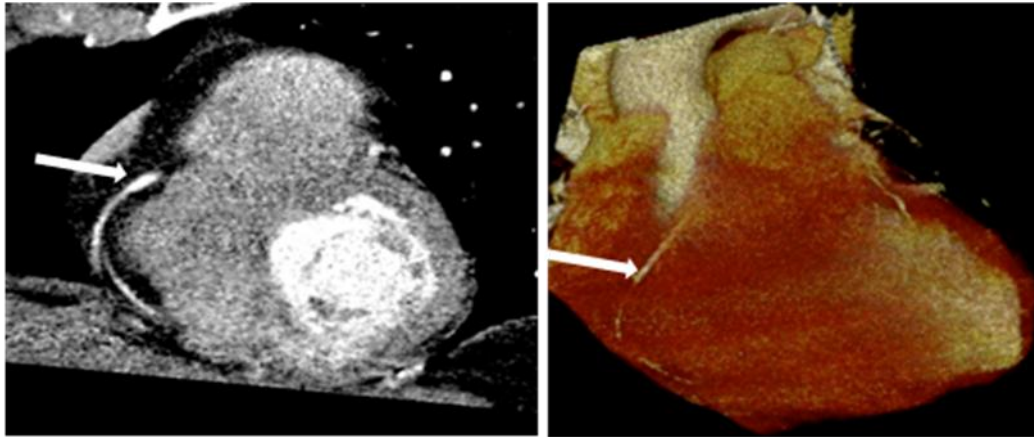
A 65-year-old symptomatic woman. Curved planar reformatted (Left) and volume-rendered (Right) CT angiography images show a noncalcified soft plaque (white arrows), which is causing a significant (70%) stenosis in the RCA
